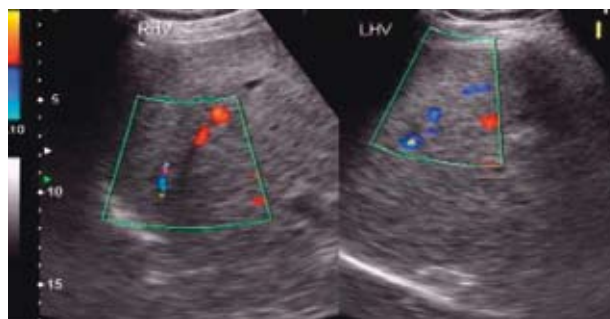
Occlusion of right and left hepatic veins on color Doppler
